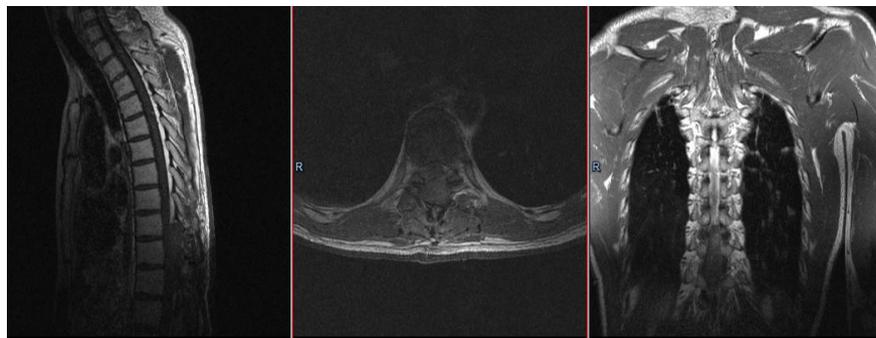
MRI control after surgery (condition after laminoplasty and removal of intramedullary formation at the level of the bodies of the Th10 and Th11 vertebrae)
